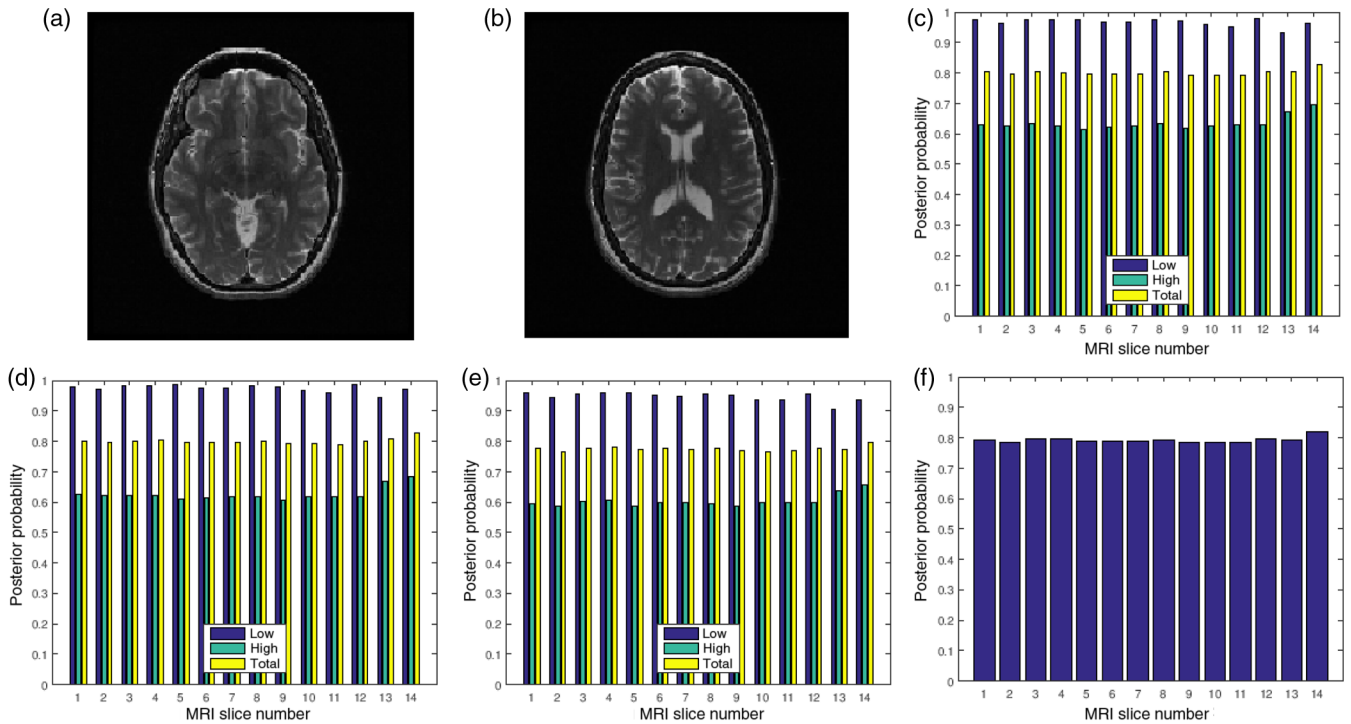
Two slices (a) slice number 1 and (b) slice number 7 in a T2 MRI volume data from NeuroRx Research Inc., (c) contrast attribute quality scores, (d) standard deviation attribute quality scores, (e) sharpness attribute quality scores, and (f) global quality score for 10 successive slices in the MRI volume data.
